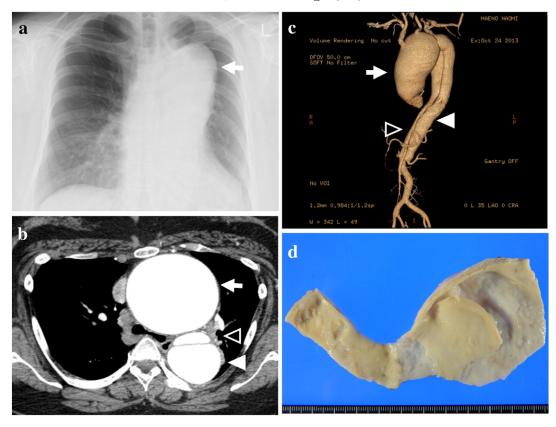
Radiographic and macroscopic findings of the resected aorta. (a) A chest x-ray showing widening of the aortic silhouette (arrow). (b) Axial image from a CT scan showing an 8-cm thoracic aortic aneurysm of the ascending aorta (arrow) and dissection (closed arrow head: true lumen, open arrow head: false lumen). (c) CTA demonstrates a thoracic aortic aneurysm (arrow) and aortic dissection (closed arrow head: false lumen). (d) Macroscopically, the aneurysmal wall of the dilated ascending aorta shows a rough luminal surface and no atheromatous plaque.
